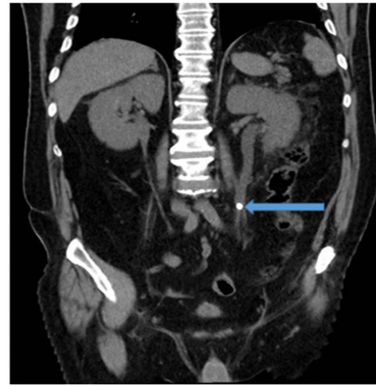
Coronal reconstruction CT scan without injection of contrast medium, parenchymal window: left ureteral lithiasis with dilatation of the upstream lumbar ureter (arrow).
